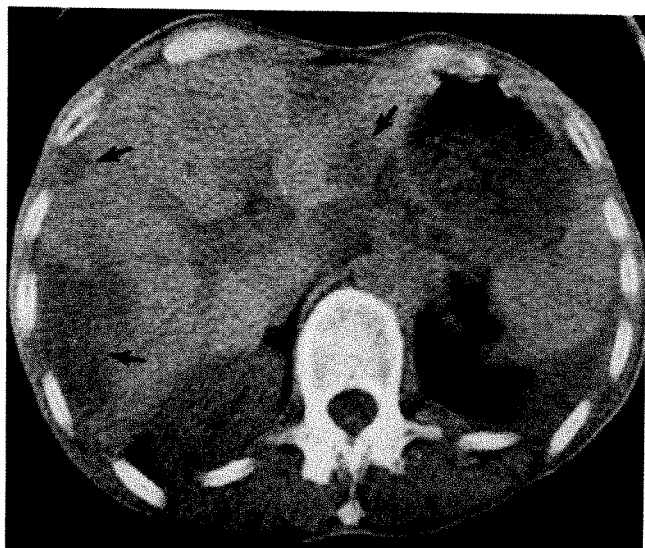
48-year-old man with weight loss and upper abdominal pain; 2 years postresection of carcinoma of colon. CT scan showing multiple areas with attenuation coefficients slightly lower than normal liver (arrows), consistent with metastases. Percutaneous needle biopsy disclosed adenocarcinoma.
